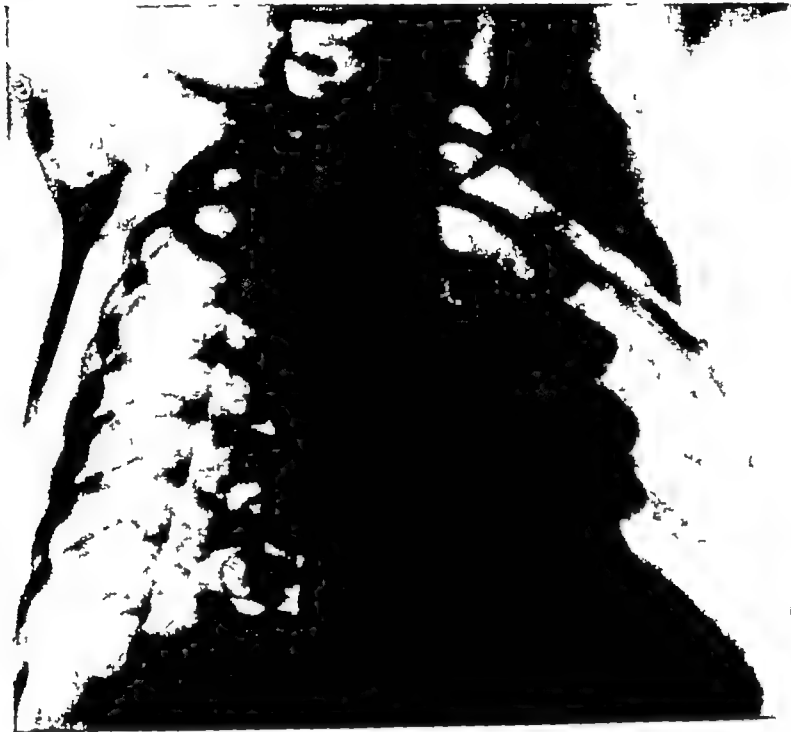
11 —Radiograph (barium swallow) showing gastric hernia and spasm of oesophagus above it in an infant who died from vomiting and haematemesis
